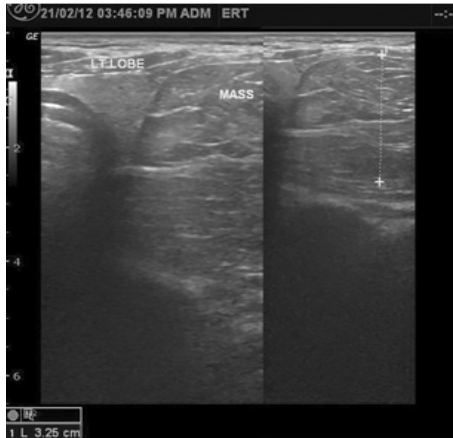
Ultrasound image showing lipoma causing compression on left lobe of thyroid gland.
